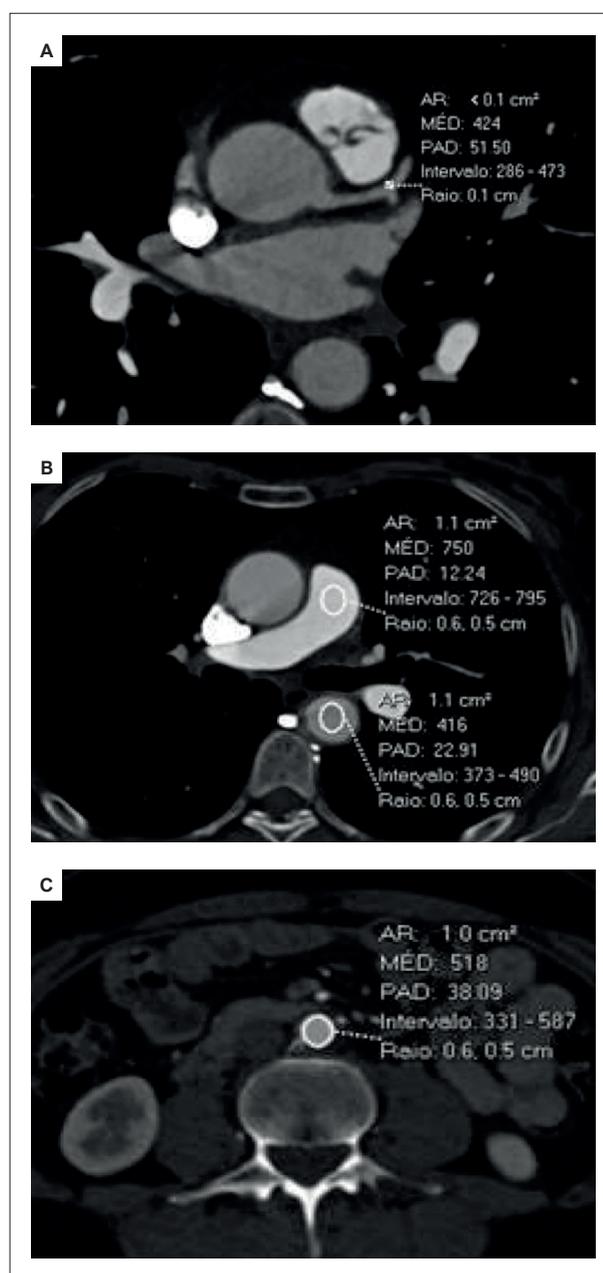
CTA in axial plane demonstrating the 4 predefined circle regions of interest to assess the attenuation measurements in the anterior descending coronary artery (A), pulmonary trunk and descending aorta (B), and abdominal aorta (C).
